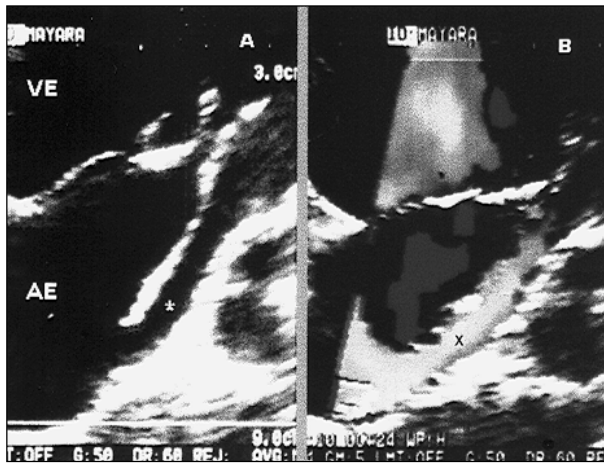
Magnification of the 2-dimensional echocardiographic data obtained on apical 4-chamber view: A) left inferior pulmonary vein (*) connected to the left atrium; B) color-flow mapping showing a laminar flow draining into the left atrium.
